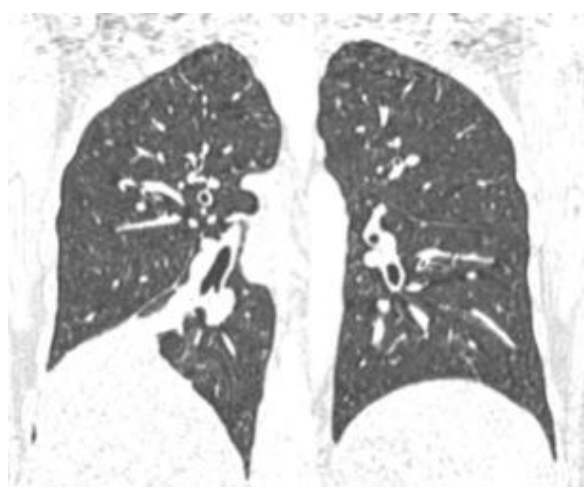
CT scan of the chest; CT scan shows a biliary fistula into the right lung cavity in the coronal plane.
